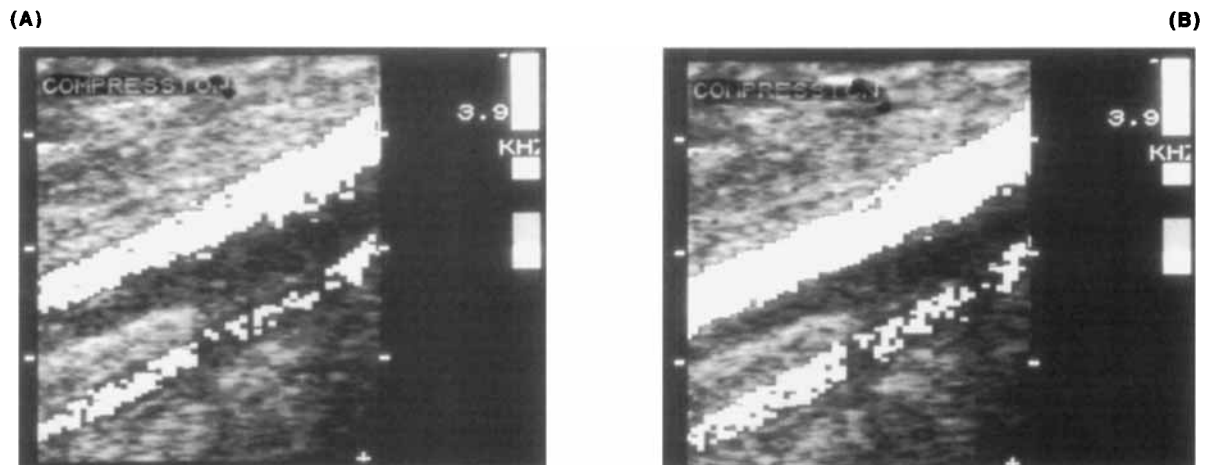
With Doppler color flow imaging, color not only indicates direction of flow, but also relative velocity. Highly saturated colors indicate slow velocities; less saturated (lighter) colors indicate higher velocities. (A) The superficial and deep femoral arteries are shown in diastole when red cell velocities are relatively slow; this is indicated by the deep saturated color. (B) Less saturated colors indicate higher velocities and signal peak systolic flow; also note that the most rapid flow is in the center of the vessel.
